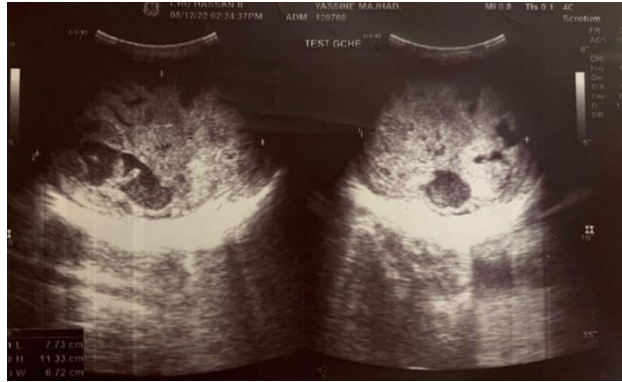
Ultrasound appearance showing heterogeneous, anechoic and echogenic images suggesting malakoplakia
